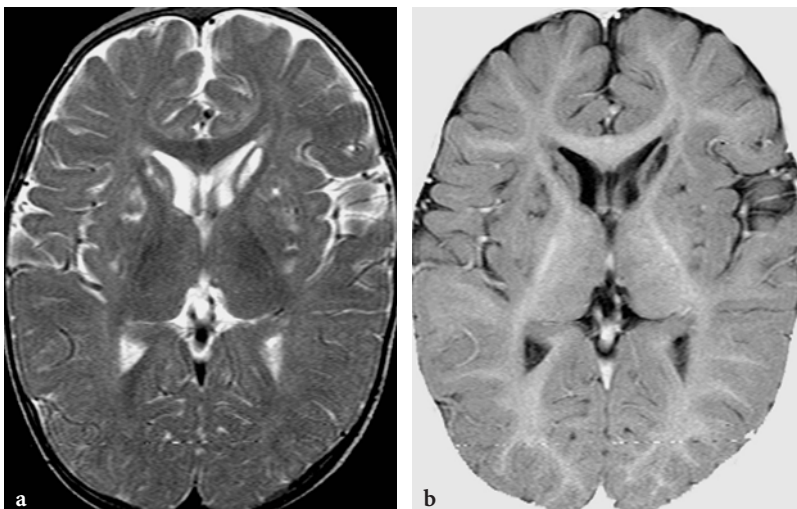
MR imaging findings in ethylmalonic aciduria in a 10-month-old male patient. a Axial T2-weighted fast spin-echo image. Inhomogeneous, patchy hyperintensities are demonstrated within the basal ganglia bilaterally. b Axial T1-weighted inversion recovery image. Basal ganglia abnormalities are well appreciated on this image. Diffuse paucity of the myelin within cerebral hemispheres (delayed and hypomyelination)
